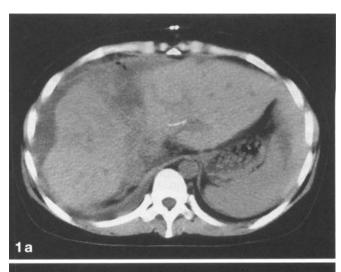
Computed tomography scans. a Two weeks after auxiliary partial orthotopic liver transplantation (APOLT). b One month after APOLT. c Two weeks after second-stage hepatectomy
